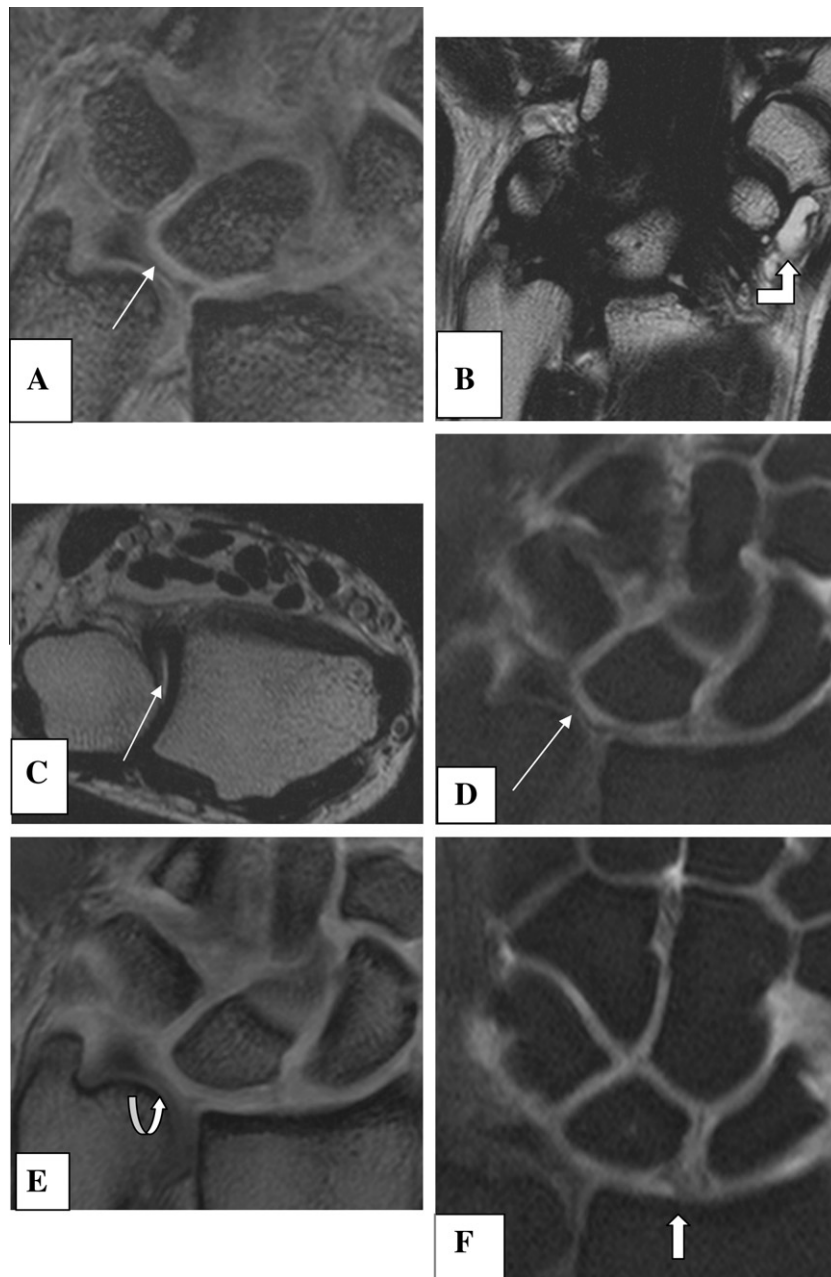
Male patient complaining of pain of the right wrist following a history of direct trauma underwent conventional MRI. Coronal T2 3D FFE (A) shows markedly attenuated central part of the TFC (arrow). Coronal T2 WI (B) shows a small ganglion cyst seen related to the scapho-trapezoid joint (curved arrow). Axial T2 WI (C) shows mild subluxation and effusion at the DRUJ (arrow). Intra articular injection into both mid carpal and radio-carpal joint compartments was performed, followed by MRA: coronal Fat suppressed T1 & T1 3D FFE MR arthrographic images (D & E) show attenuation of the central TFC, with intra substance enhancement (straight and curved arrows), yet with no definite tear. (F) Coronal T1 Fat suppressed image shows bright contrast signal traversing the SL (scapho-lunate) ligament suggesting partial tear.
